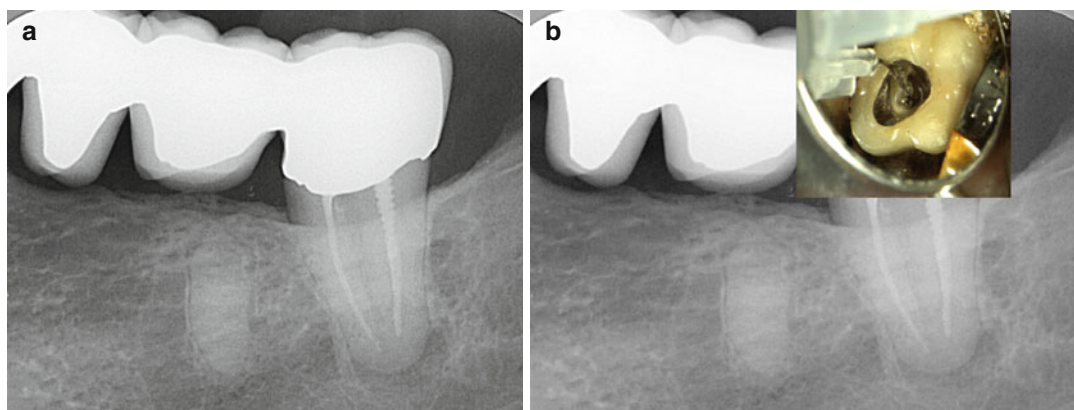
(a–h) Persistent apical periodontitis in tooth 37. Abutment in a full arch bridge. Referred for endodontic surgery. CBCT shows difficult surgical access and a
